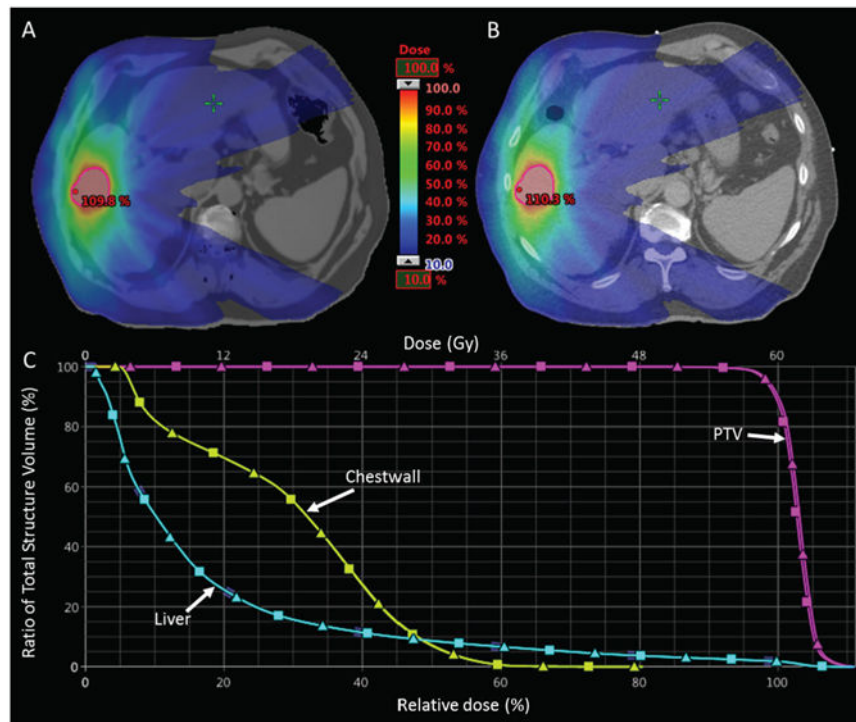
Relative dose distributions optimized on MRCT (A) and recalculated on standard CT (B). The DVH curves for the PTV, Chest wall and Liver are shown in the bottom panel (C) where MRCT DVHs are represented by squares and CT DVHs are triangles. Note the close proximity of the rib relative to the target (outlined in red).
